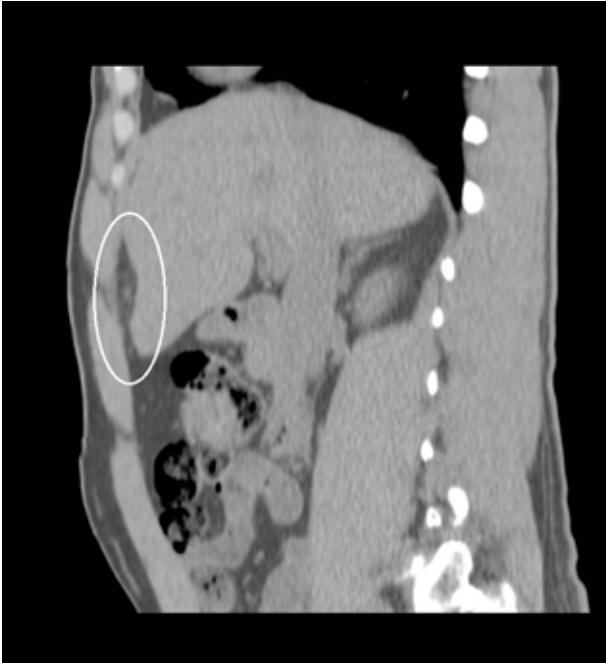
Sagittal CT image depicting the longitudinal extent of the lipomatous appendage and the mass effect on liver surface with a prominent inward bulging. Also in better detail the extent of the fat stranding, and the “dot sign”, as similarly described by Uyttenhove F et al. in their case report³, caused by thrombosis of the vessels in the center of the lipomatous appendage.
